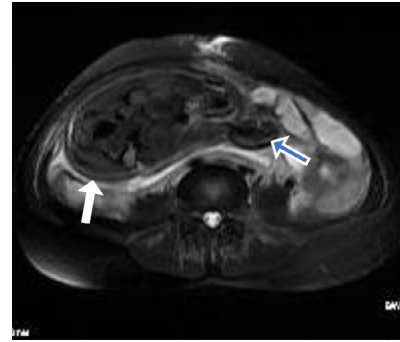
Axial MRI: radiologists mistakenly regarded the amniotic sac wall as the uterine wall of right cornual pregnancy (white arrow). Fetal hand protruded into the patient's abdominal cavity (blue arrow). (Color version of figure is available online)
